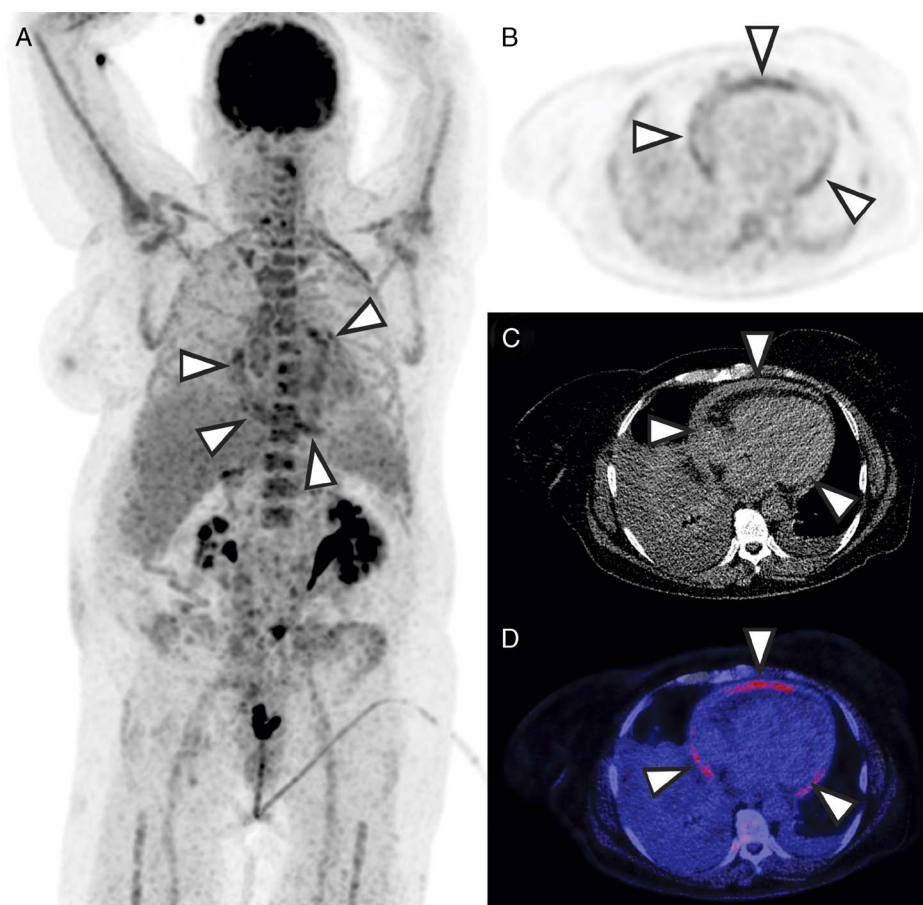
A 56-year-old woman underwent surgical debulking (ileocecal and sigmoid resection, with creation of a colostomy) because of recurrent cervical cancer. After surgery, she developed fever and de novo atrial fibrillation. Full-dose diagnostic CT (not shown) demonstrated pleural and pericardial fluid collections but no other acute pathology. Despite the use of intravenous meropenem, the fever persisted. Leukocyte and CRP levels were 14.7×10^9 and 156 mg/L, respectively. Blood cultures were positive for *Enterobacter aerogenes*. FDG-PET/CT was performed for depicting infectious foci. Coronal maximum intensity projection FDG-PET (A), axial FDG-PET (B), low-dose CT (C), and fused FDG-PET/CT (D) at the level of the heart showed foci of increased pericardial FDG uptake and diffuse pericardial fluid and thickening (arrowheads), indicating pericarditis. FDG-PET/CT detected no other infectious foci.
